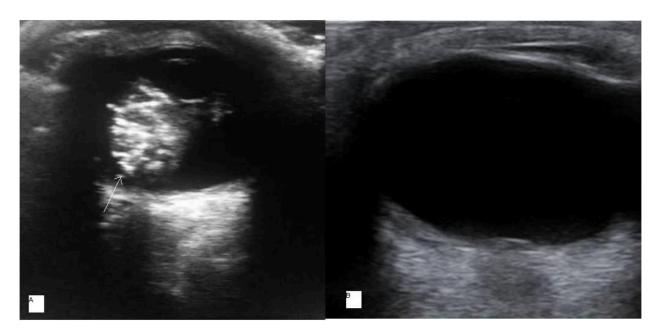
B mode ultra sonogram image showing tumor(arrow in A) in stage D retinoblastoma of 11 months old baby. Total resolution of the tumor is seen after 3 sessions of intraarterial chemotherapy as seen in B.
